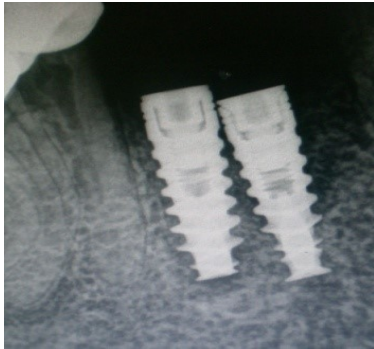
Radiograph – closely positioned implants.
